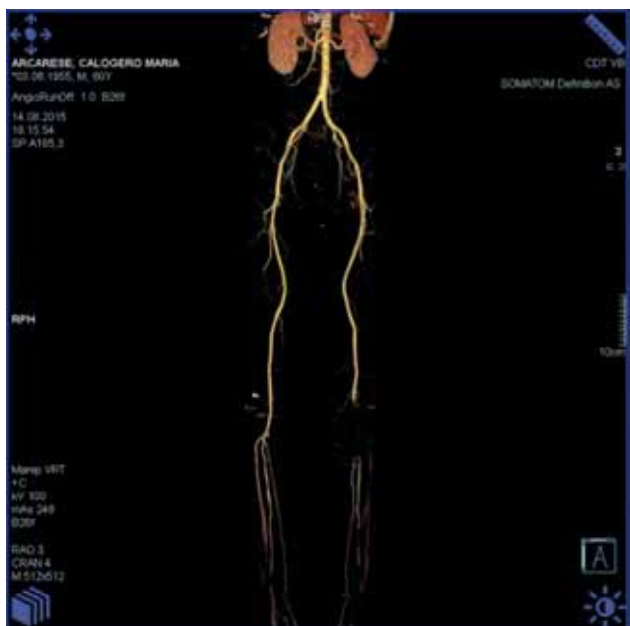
Angio CT for lower limb describes the absence of blood stream in the terminal level of left popliteal artery, the emergencies and proximal levels of anterior and posterior tibial arterieris and fibular artery up to the linkage between the upper third with the lower two thirds of gluteal region
